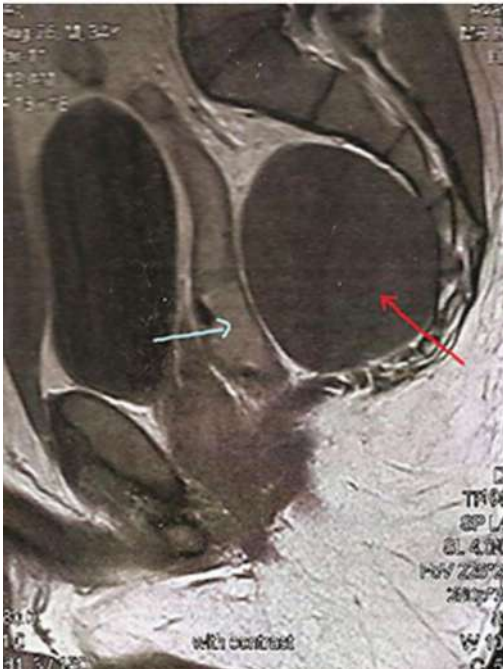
MRI Imaging sacral mass.
